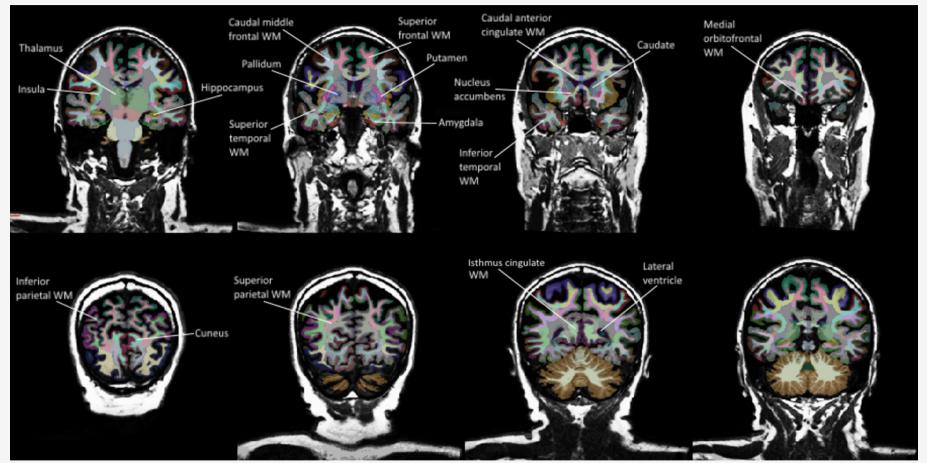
FreeSurfer segmentation of HIV- brain Example of FreeSurfer segmentation of volumes of interest in coronal MRI slices of an HIV- control.
